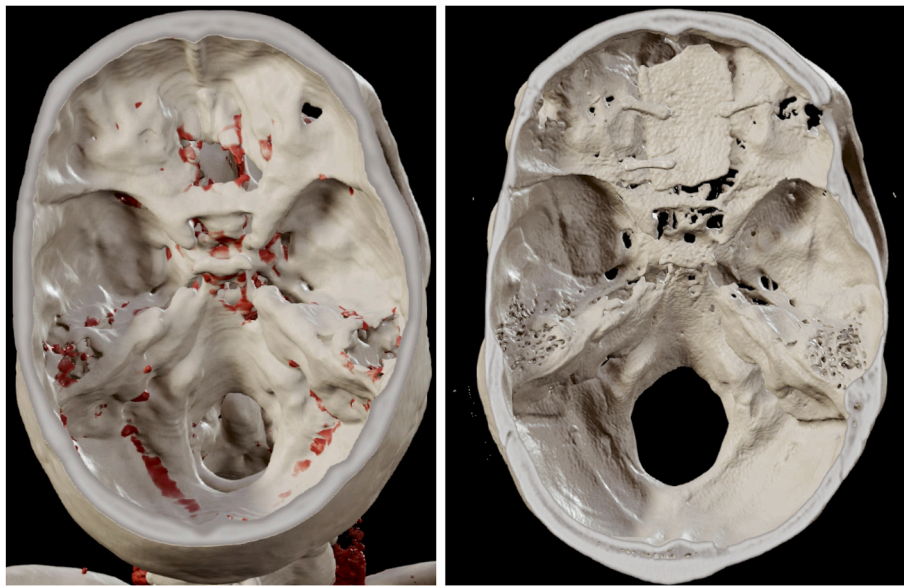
Pre- (Fig. 2 A) and postoperative (Fig. 2 B) CT scans showing a 3D-reconstruction of the frontobasal bone defect (size 12.3 cm²) of patient No. 10, which was covered with an autologous tabula externa bone chip.
